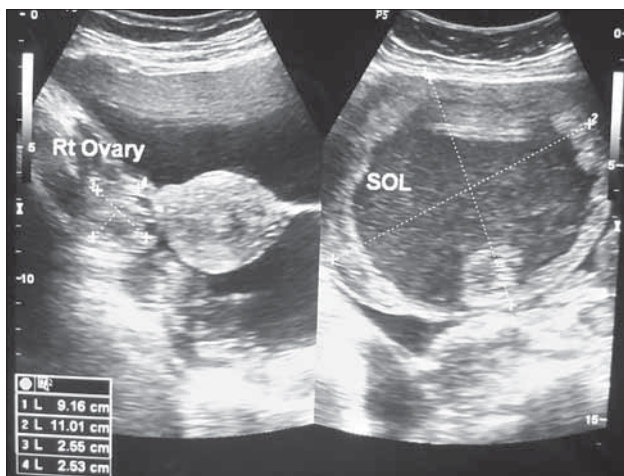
Ultrasonography of abdomen showing ovarian space occupying lesion
